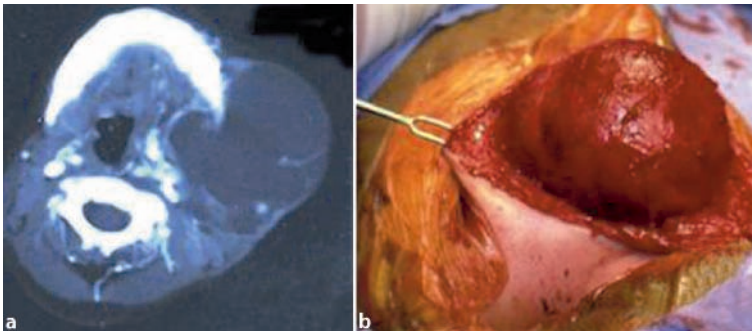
Lymphatic malformation involving the submandibular gland in a 3-year-old girl. a CT scan with intravenous (IV) contrast showing a large, cystic lesion originating from the left submandibular triangle. b Surgical excision
